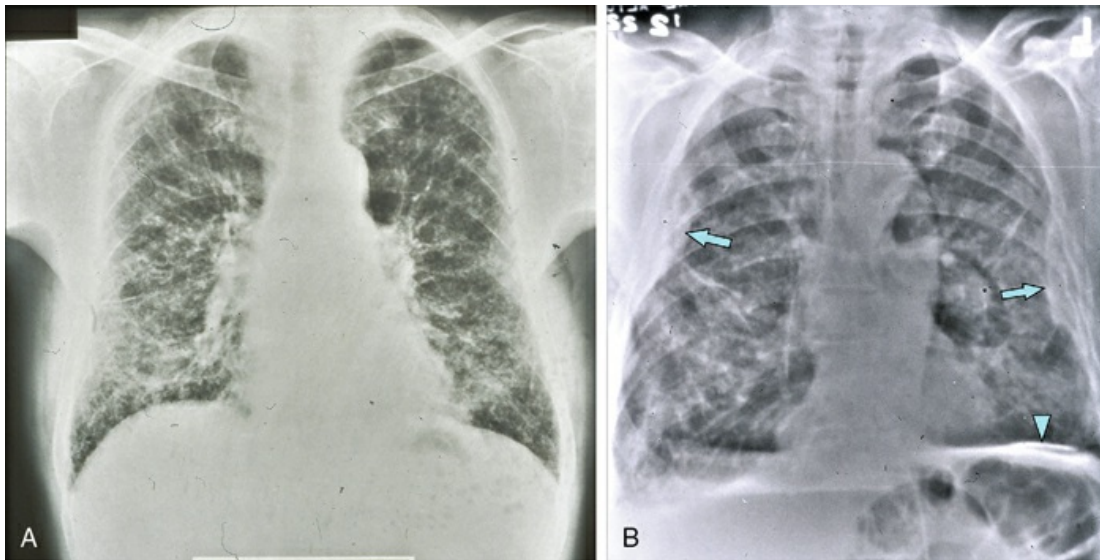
Chest radiographs showing parenchymal and pleural disease secondary to asbestos exposure. A, Extensive interstitial lung disease in a patient with asbestosis. B, Increased interstitial markings and pleural disease (arrows) with diaphragmatic calcification (arrowhead), due to prior asbestos exposure.
